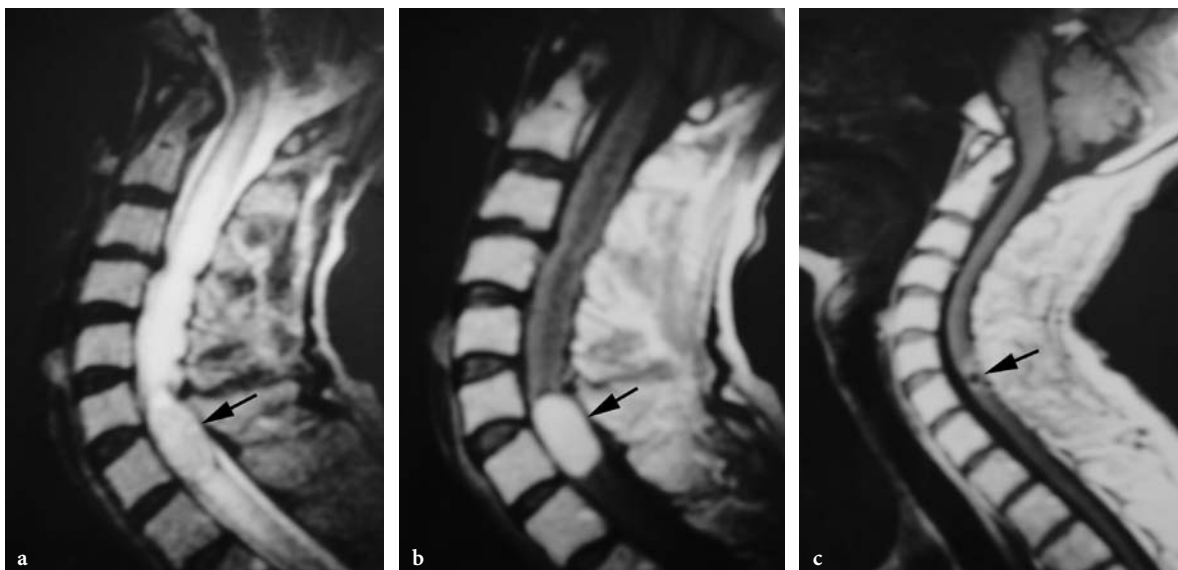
Spinal cord metastasis as a first manifestation of renal cell carcinoma in a 70-year-old woman who developed Brown-Sequard syndrome within 6 weeks. a Sagittal T2-weighted MR image of the cervical spine demonstrates a solitary lesion (*arrow*) at the level of C7 isointense to the spinal cord, but slightly bulging its contours. The hyperintense areas above and below the lesion correspond to edema. b Sagittal contrast-enhanced T1-weighted MR image displays a clear enhancement of the well-demarcated intramedullary lesion (*arrow*). The edema is now hypointense but less so than the cerebrospinal fluid. c Sagittal contrast-enhanced T1-weighted MR image obtained 6 weeks after surgery shows surgical sequela at the site of the tumor (*arrow*), which has been completely removed, and the complete disappearance of edema. (Image courtesy of O.E.M. SCHIJNS)
